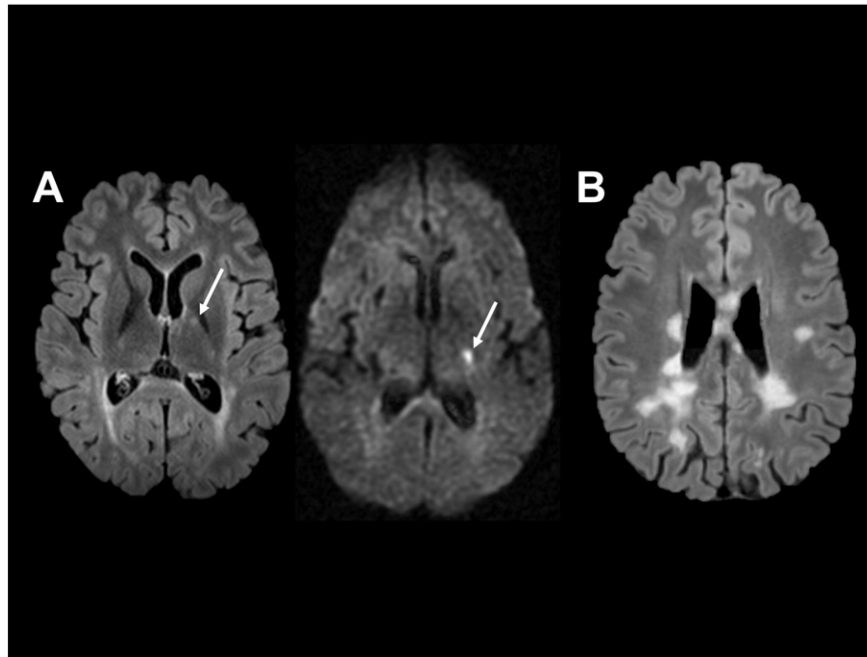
A: Left, axial T2-weighted fluid-attenuation inversion recovery (FLAIR) image from a 33-year-old woman with MS, showing a focal lesion in the posterior limb of the left internal capsule. Right, axial diffusion-weighted image showing an acute lacunar infarct in a similar location. B: Axial FLAIR image from a 36-year-old man with relapsing-remitting MS, showing extensive involvement of the white matter.
